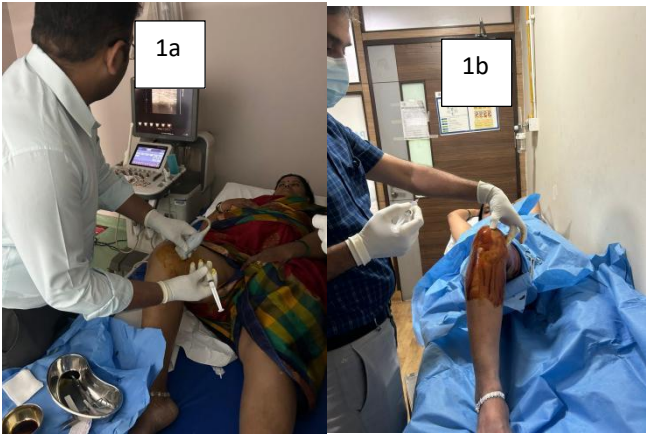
A Anatomical Landmark Guided MGNB & Fig 1 B Ultrasound Guided MGNB
